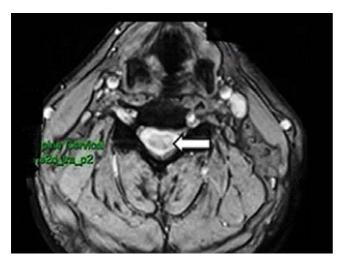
T2 weighted MRI axial image of the spine showing an intramedullary lesion within the cervical cord (arrow).
